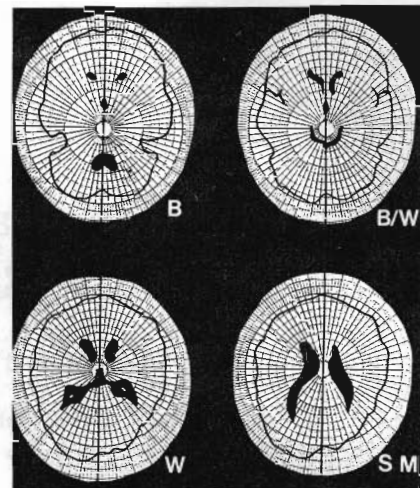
Method for measuring computed tomographic scan occipital lengths (bottom) and frontal lengths (top). In this case, occipital length asymmetry on slice W was 3-mm difference, with left greater than right. Asymmetry value was +30. Asymmetry value on slice SM was +40. Similar methods were employed in measurement and calculation of frontal lengths on slices B and B/W, and of posterior parietal lengths on slices SM + 1 and SM + 2.
